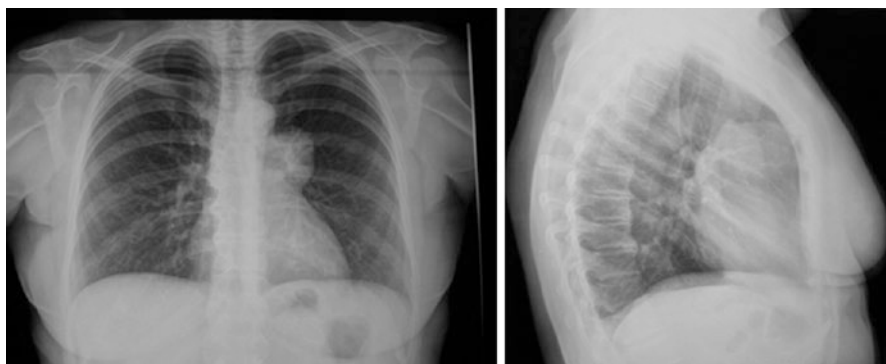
Chest X-ray: thymic cyst. Radiopaque nodular formation is observed at the level of the II aortic arch
